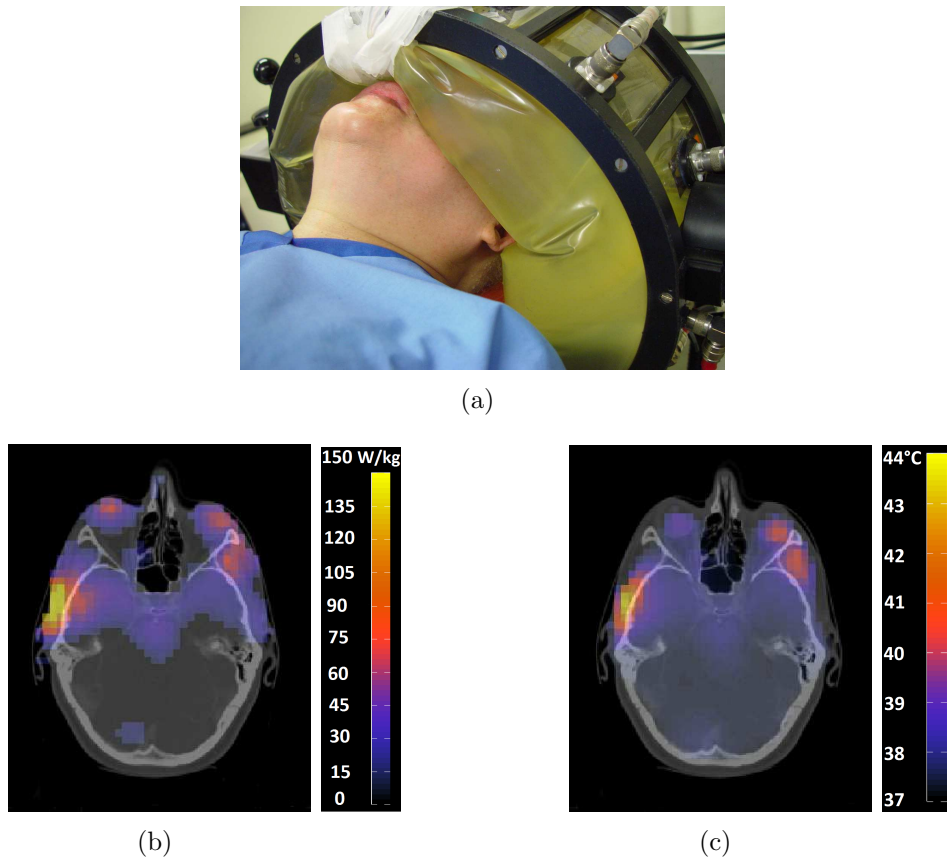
Picture of the HYPERcollar system in clinical use (a). Example of the predicted SAR (b) and Temperature (c) distribution on the planning CT.
